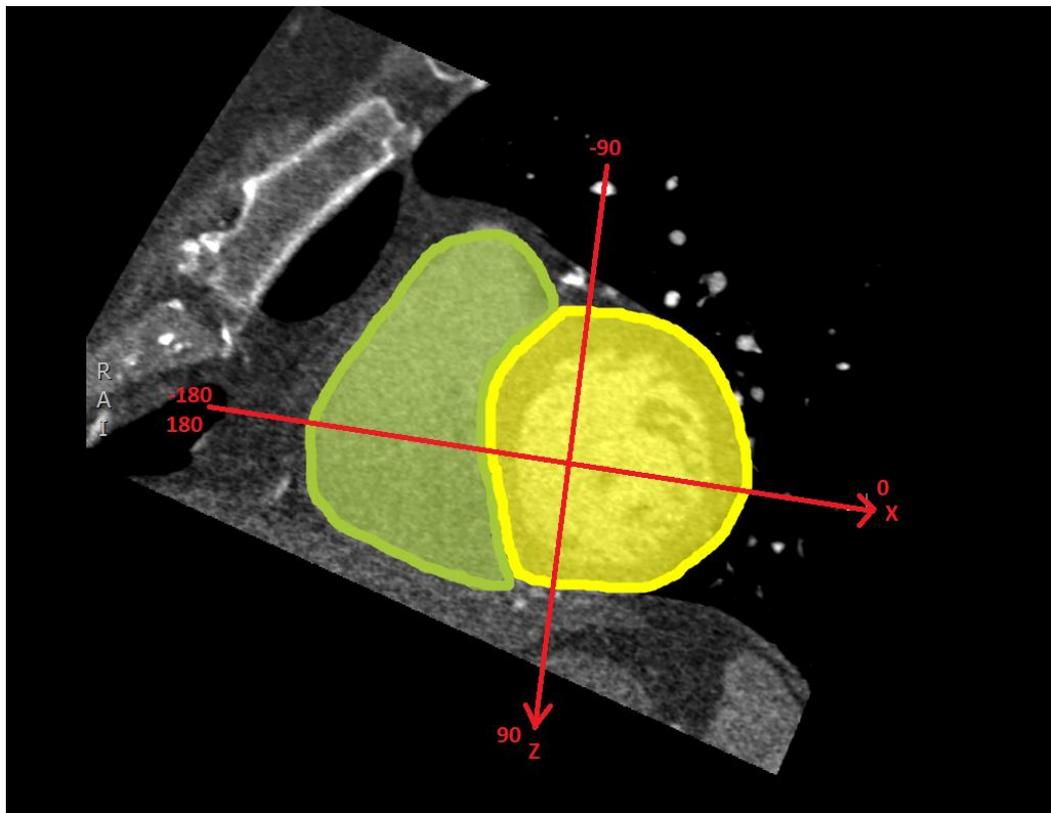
Cardiac CT section taken in the same plane as the CGM XZ plane, demonstrating the orientation of the XZ plane in relation to the heart in the thorax. Green shading represents the right ventricle; yellow shading represents the left ventricle. Note that the XZ plane takes a short axis view through the heart and the plane contains similar amounts of both the left and right ventricle.
